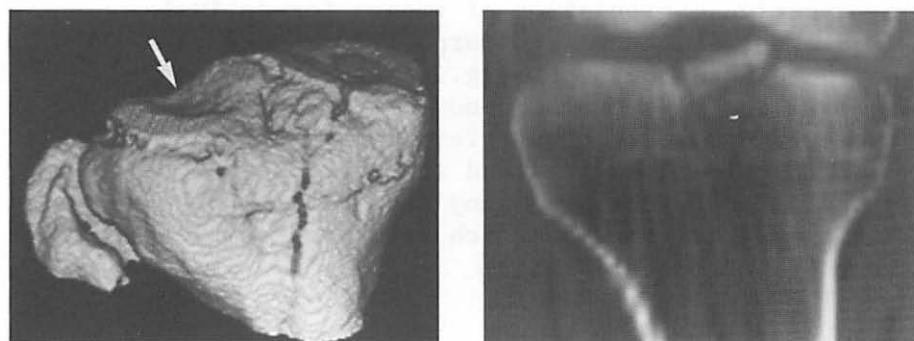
3-D image showing minimal depression of posterior aspect of lateral plateau (arrow) not appreciated on original CT sections or reconstruction (b). Note extension fractures involving tibial spines.
